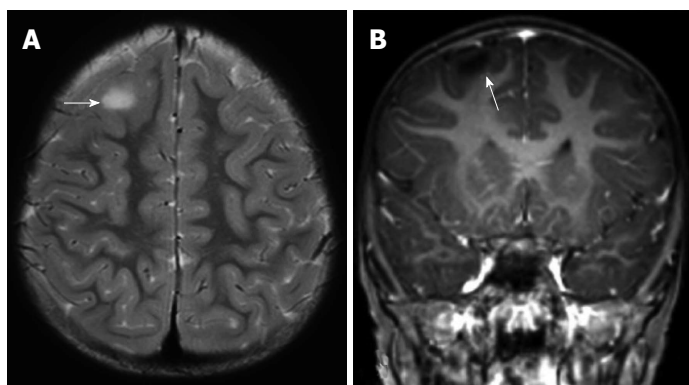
Focal cortical dysplasia type IIb of the left frontal cortex in a 3-year-old girl. Axial T2-weighted (A) and coronal T1-weighted (B) magnetic resonance images reveal a slight increase of white matter signal on T2-weighted image, significant blurring on T1-weighted image in gray matter-white matter junction (arrow).
